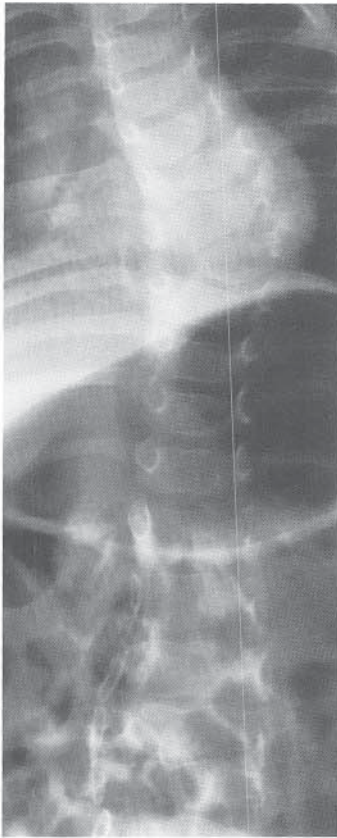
Congenital abnormalities of the spine associated with myelomeningocele. Spinal dysraphism and congenital vertebral anomalies are often best appreciated on infant films. In all infants with myelomeningocele, radiographs of the entire spine should be obtained and studied for evidence of these deformities. This radiograph demonstrates opening of the posterior spinal elements from the L1 level, a hemivertebra at T8, and a butterfly vertebra at T6.
